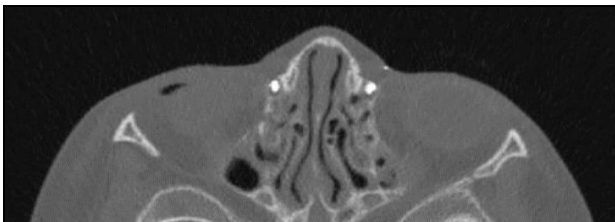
A Dacryo-Computed tomography of the naso-lacrimal duct axial view showing bilateral fistula.
